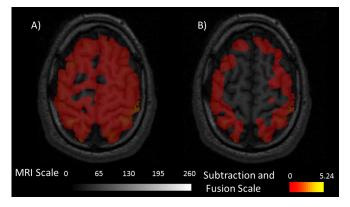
Axial view for high level subtraction image (A) and fusion image (B) coregisted with MRI.
